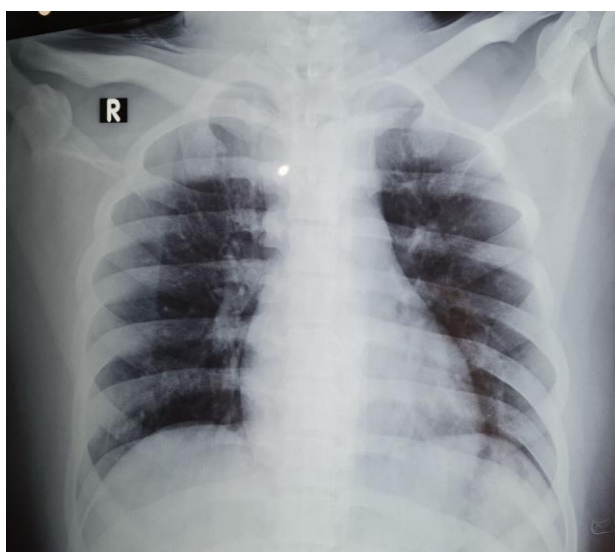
Chest Radiograph Showing Normal Lung Fields and Mediastinum in a Patient with Ludwig's Angina
